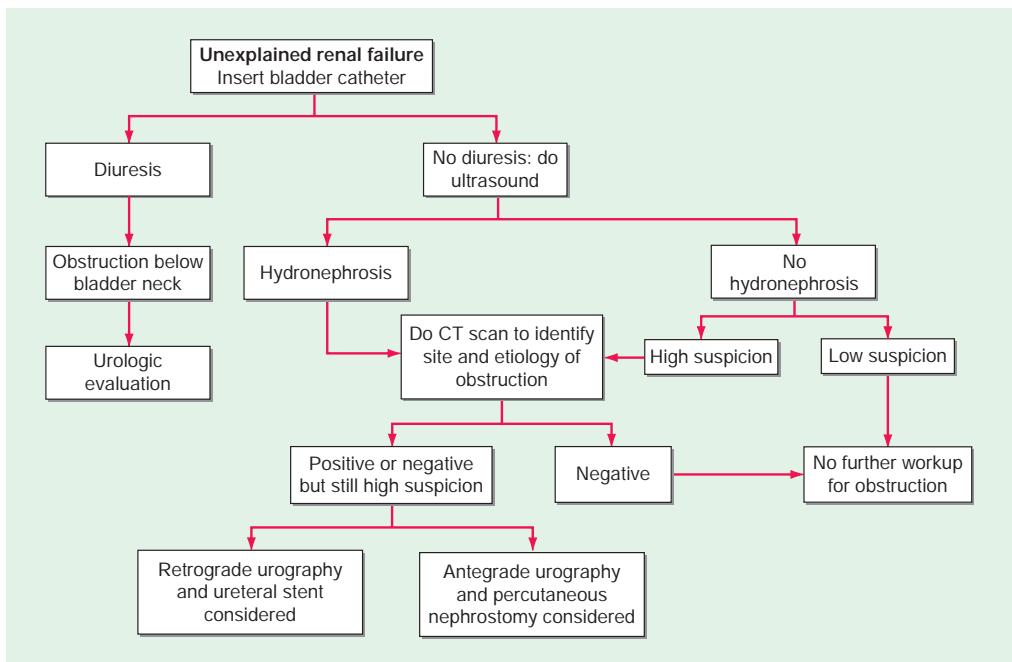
Diagnostic approach for urinary tract obstruction in unexplained renal failure. CT, computed tomography.
